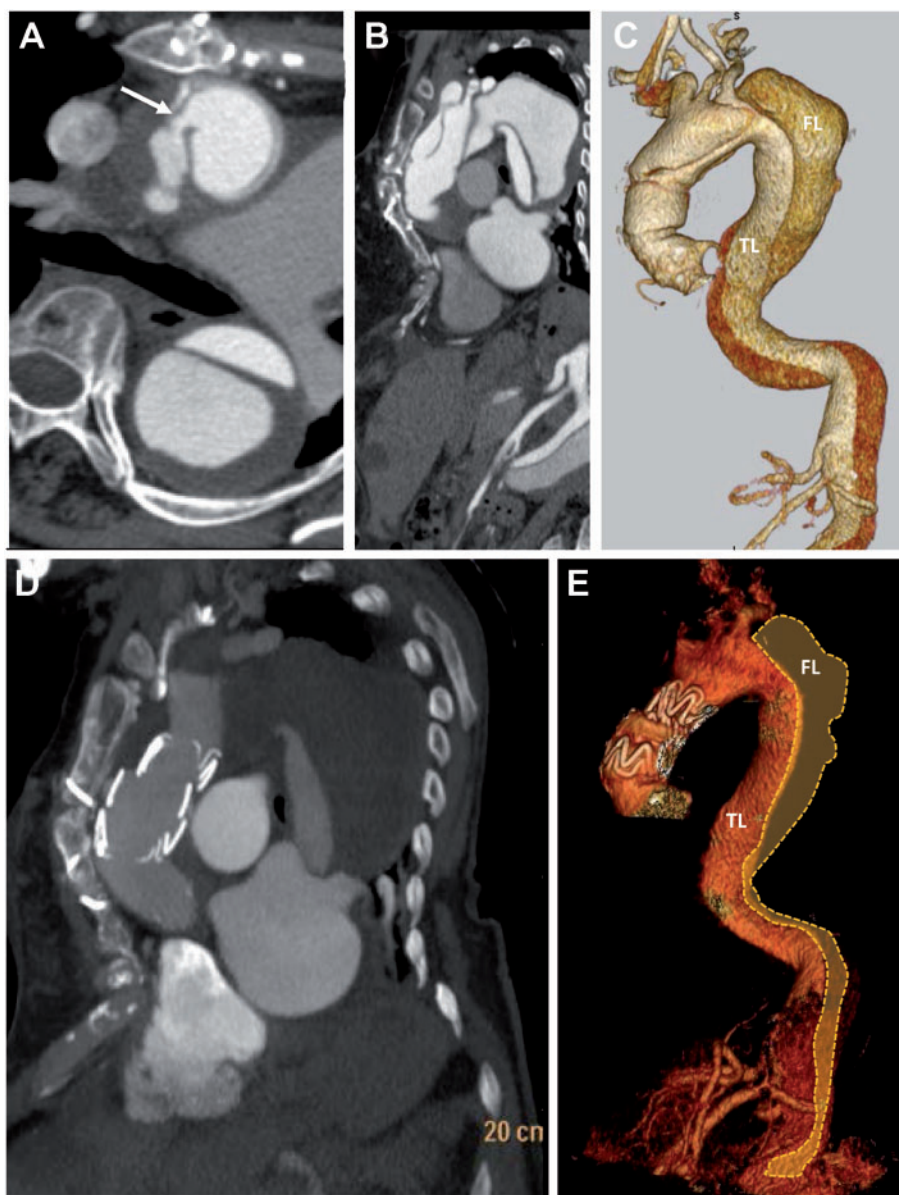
A 62-year-old female with a DeBakey type I dissection following an aortic valve repair plus ascending prosthetic graft replacement. Preoperative computed tomography angiography (A) with multiplanar (B) and volume rendering 3D (C) reconstructions shows the entry tear (A, white arrow) in the ascending aorta with a dilated false lumen and a non-collapsed true lumen. Postoperative computed tomography angiography with multiplanar (D) and volume rendering 3D (E) shows the complete remodeling in the ascending aorta with the complete thrombosis of the false lumen (orange area). FL: false lumen; TL: true lumen.
